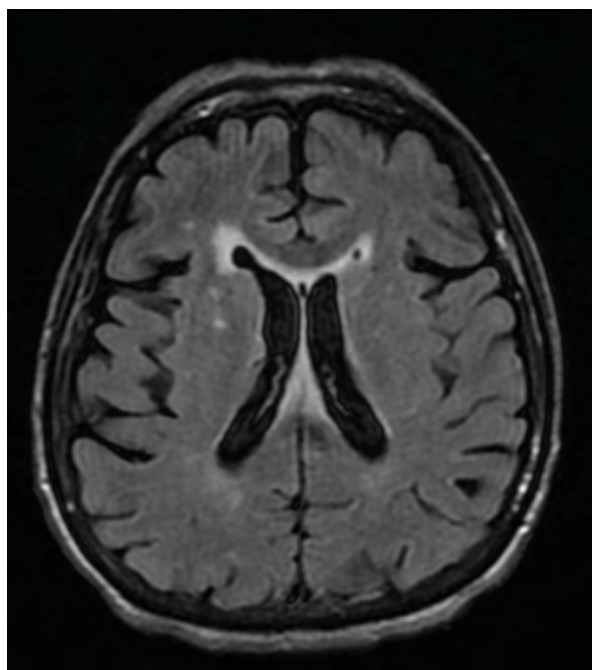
Brain MRI. T2 FLAIR. Cortical and subcortical atrophy. Leukoaraiosis
